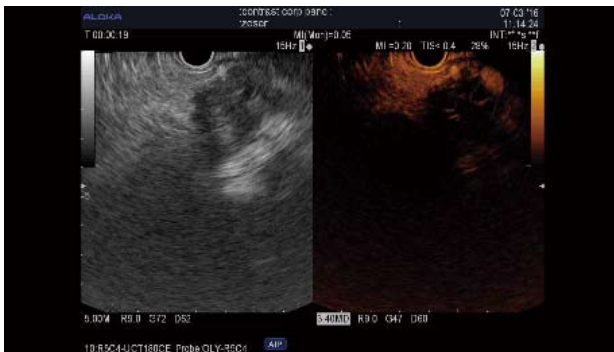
Contrast-enhanced harmonics-endoscopic ultrasound of pancreatic adenocarcinoma. Standard endoscopic ultrasound image (left) of a hypoechoic lesion of the pancreatic body. The contrast-enhanced image (right) shows a hypoechoic adenocarcinoma. The dilated pancreatic duct is seen upstream of the lesion.
